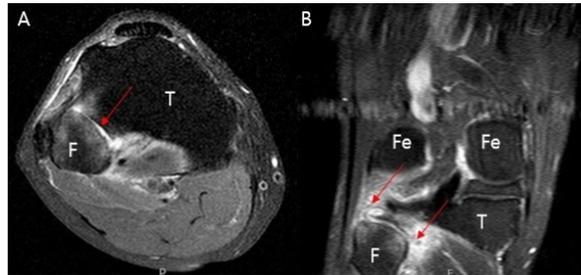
Right knee MRI. Axial fat-saturated proton density MR image(Figure 2A) and coronal gadolinium-enhanced fat-saturated T1-weighted image(Figure 2B) showed arthritis at proximal tibiofibular joint, with adjacent bone marrow edema and soft tissue swelling(arrows). Fe indicates femur, T : tibia, F : fibula
